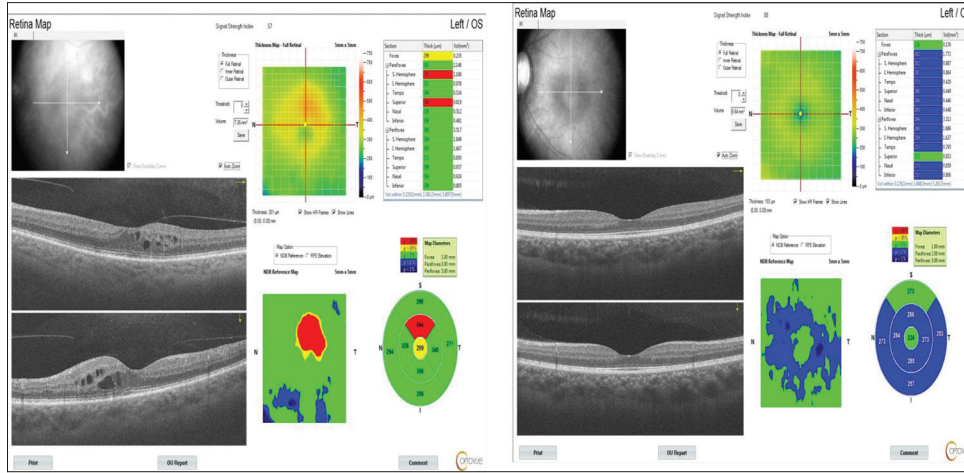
CT of preinjection and postinjection case no. 1. OCT, optical coherence tomography.
